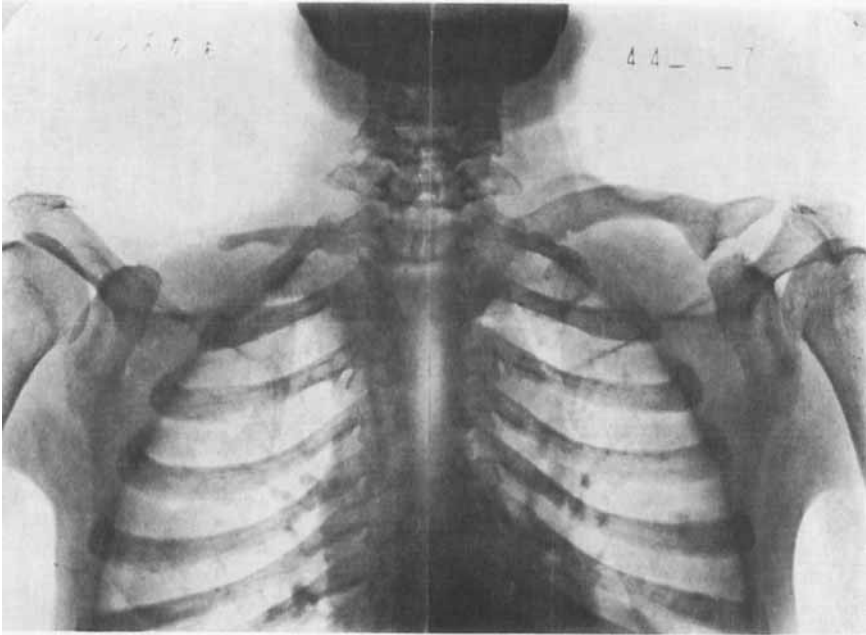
Roentgenogram of upper chest. Case 1. The lateral two thirds of the right clavicle was completely absent and the remaining part was hypoplastic. Slight hypoplasia of the acromial end of the left clavicle was present. The residual acromion growth plate was seen on the left side.
